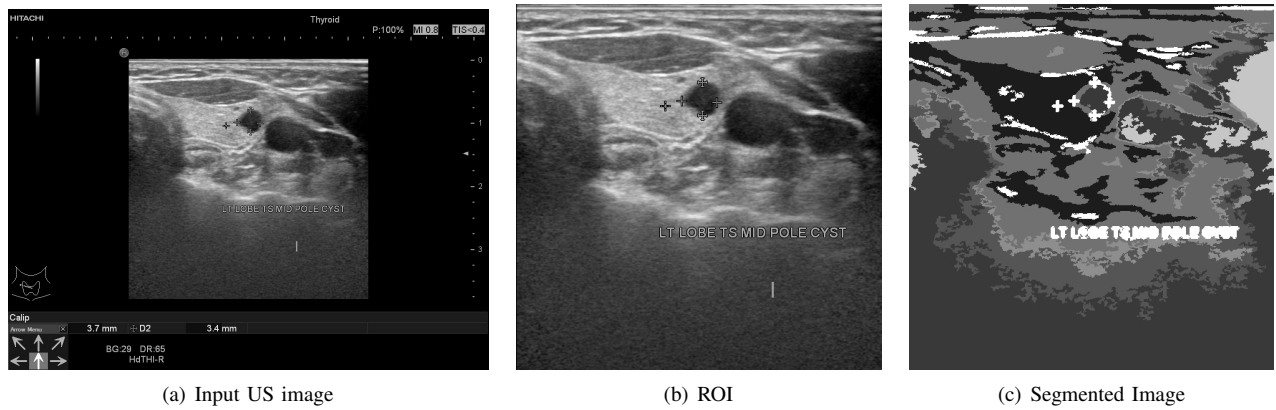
Automatic cluster estimation and unsupervised segmentation of the ultrasound image of a thyroid gland showing false positive classification of pixels due to manually induced artefacts.
